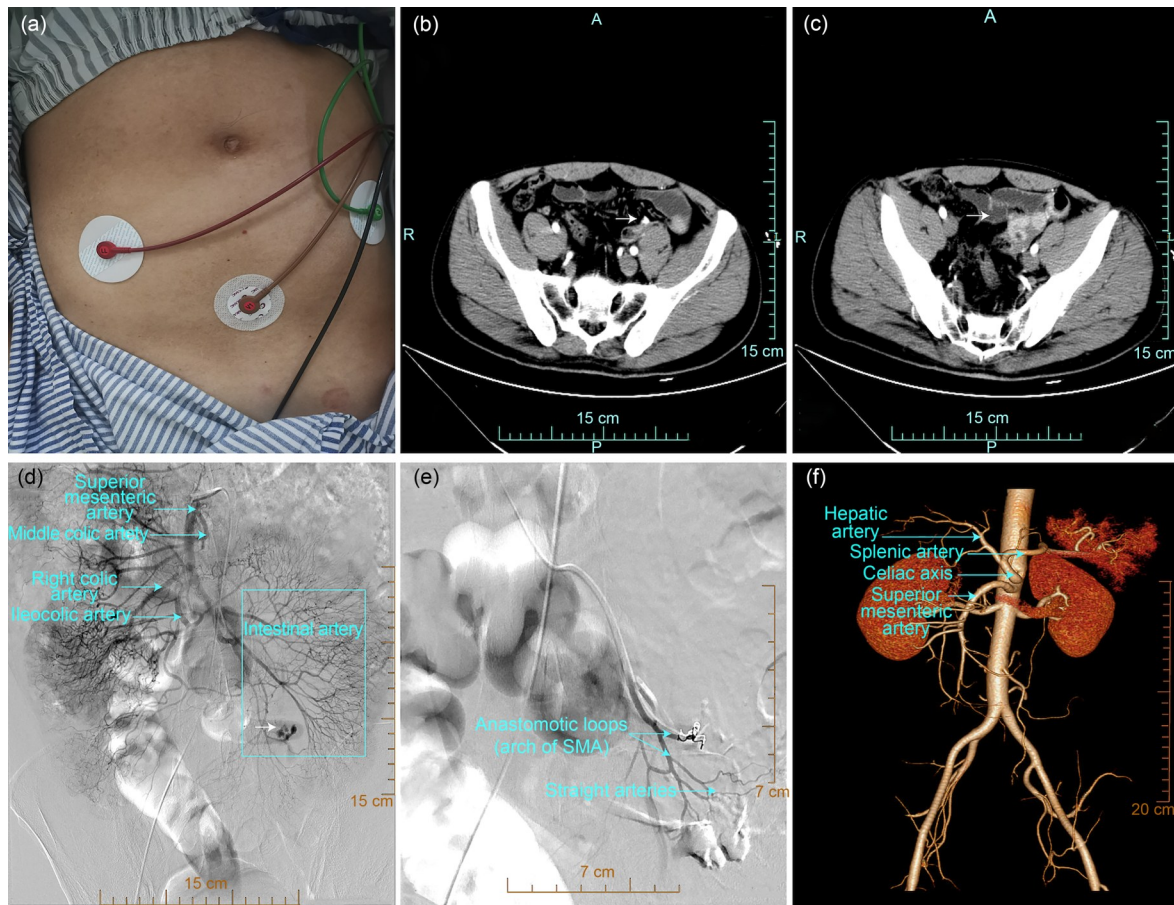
Diagnosis and treatment of patient with isolated superior mesenteric artery rupture. (a) No abnormal changes were observed upon abdominal inspection. (b, c) The abdominal computed tomography (CT) suggested the ruptured superior mesenteric artery (arrow in b) and blood accumulation around the small intestine (arrow in c). (d) Digital subtraction angiography (DSA) revealed extravasation of contrast medium (white arrow). (e) No extravasation of contrast medium was seen on the angiographic review after treatment. (f) The lumens of the superior and inferior mesenteric arteries were well filled with contrast medium, and there were no signs of stenosis or dilation. A: anterior; R: right; L: left; P: posterior.
